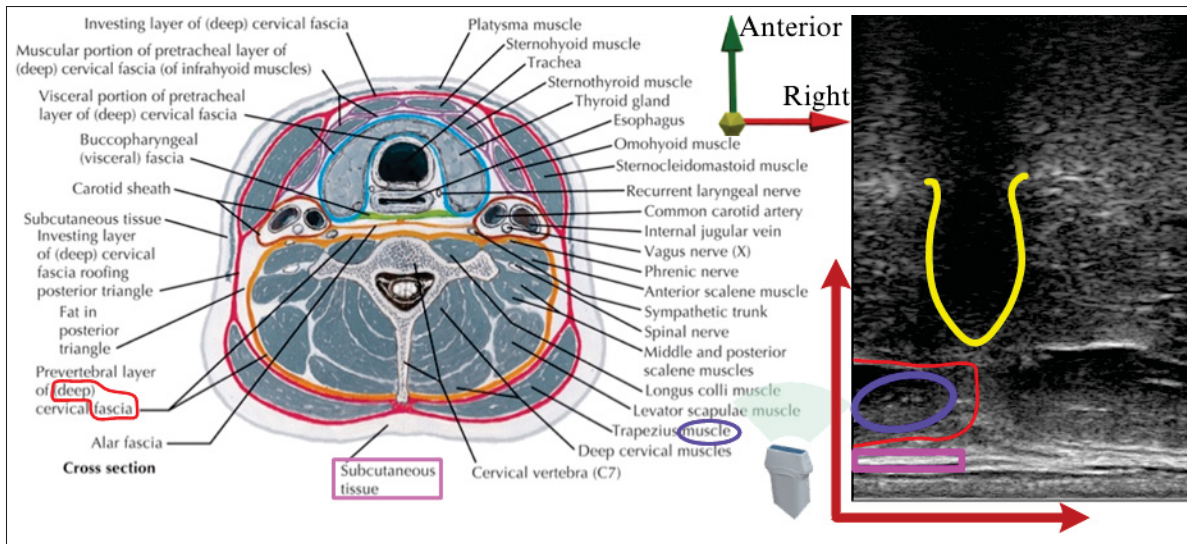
Soft tissue interpretation in axial spinal ultrasound images
